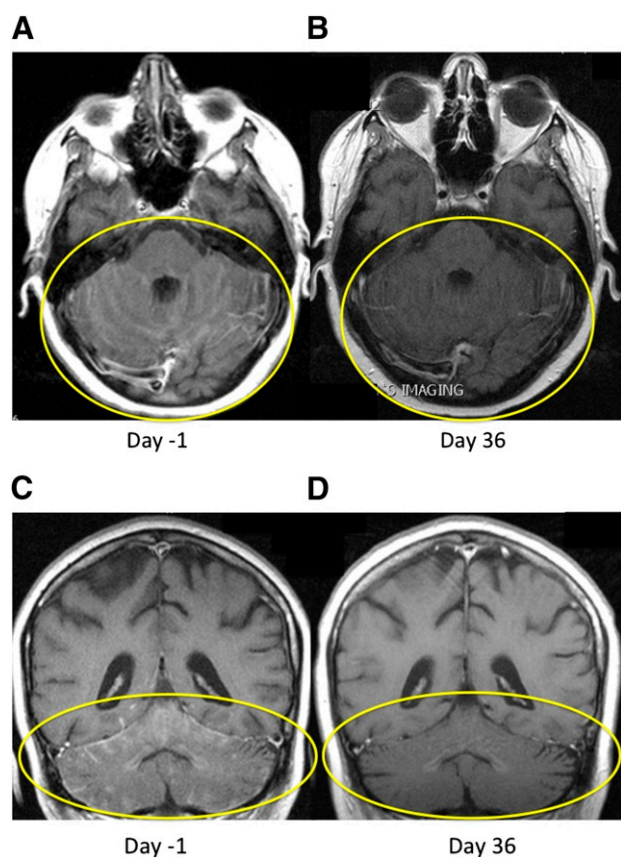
Images of the cerebellum before and after 6 weeks of alectinib treatment, showing resolution of the meningeal enhancement. (A, B): Axial magnetic resonance imaging (MRI). (C, D): Coronal MRI images of the cerebellum before and after 6 weeks of alectinib treatment showing resolution of the meningeal enhancement.
